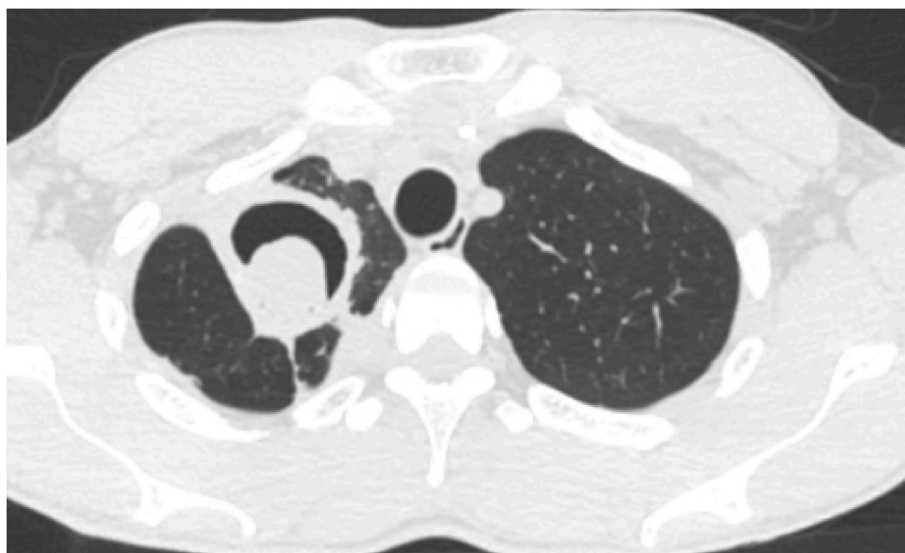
Chest CT on admission, showing right upper lobe cavity with aspergilloma.
